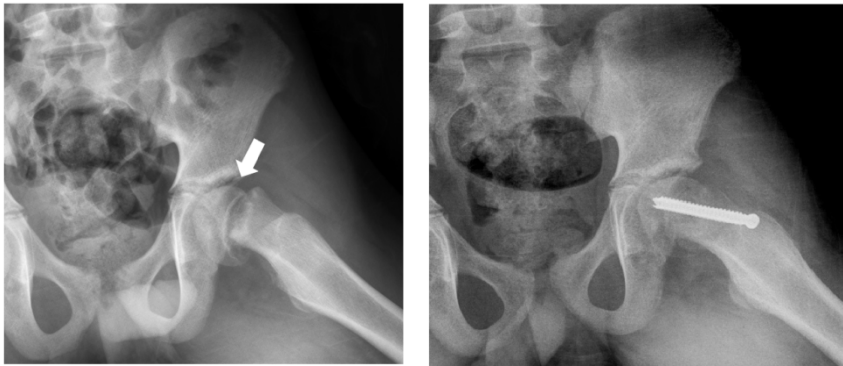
(Left) Presenting radiograph of a child with slipped capital femoral epiphysis. The proximal epiphysis is displaced posteriorly on the femoral neck (arrow). (Right) Hip radiograph showing fixation of the slipped capital femoral epiphysis with a single screw into the hip.
